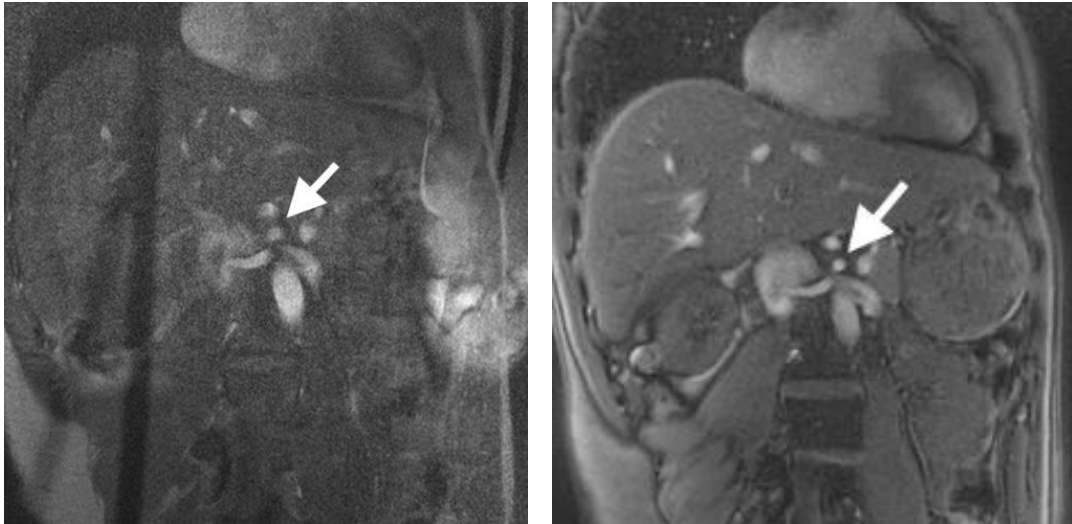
Respiratory triggered, cardiac gated (left) versus R-R interval averaged golden angle spiral (RAGS) (right) phase-contrast MRI of the superior mesenteric artery (arrows; magnitude images).
